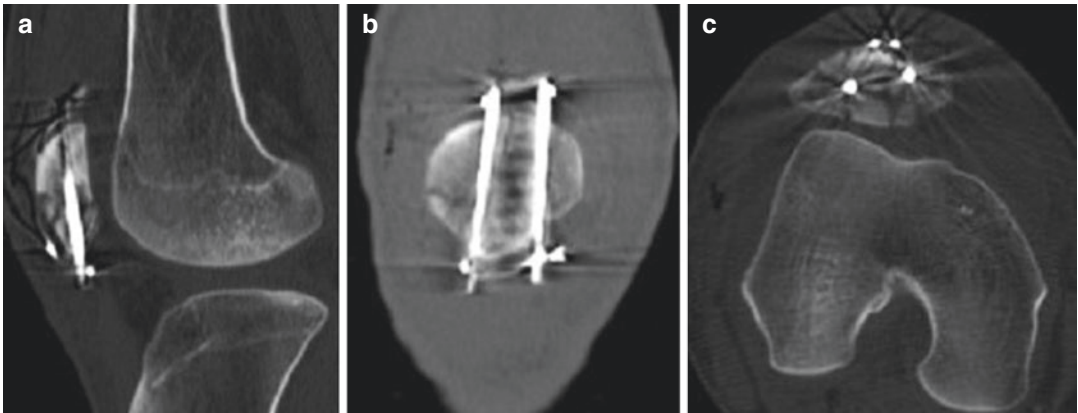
(a–c) Post-operative sagittal, coronary, and axial CT images
